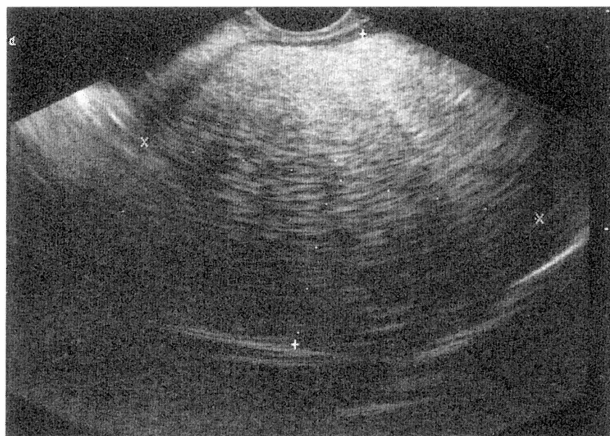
Transvaginal ultrasound demonstrates a hyper-echoic mass 8 x 8 cm in diameter in the pelvis.
